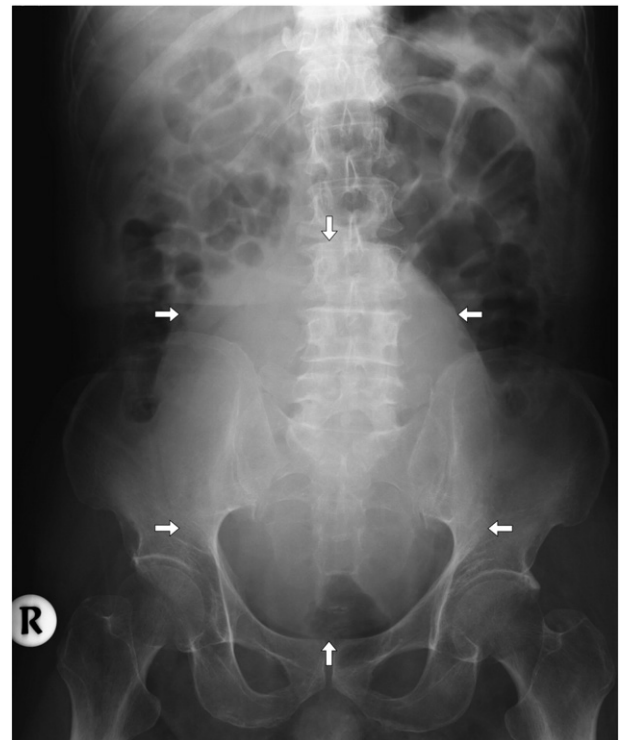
Abdominal radiograph showing a ‘full-moon’ shadow (arrows) in the lower abdomen, with severe compression of the adjacent colon.
